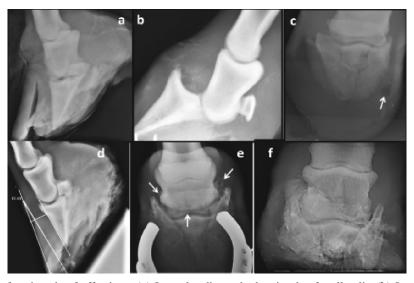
Radiographs of various hoof affections. (a) Lateral radiograph showing hoof wall split, (b) Lateral radiograph showing dislocation of coffin joint, (c) Dorso-plantar radiograph showing a smooth marginated, radiolucent defect in the solar region suggestive of solar abscess, (d) Lateral radiograph showing laminitis with severe rotation of coffin bone, (e) Dorso planter radiograph showing proliferative bone reaction and lytic changes in the navicular bone suggestive of navicular disease, (f) Dorso-palmer radiograph showing bone reaction in coffin joint.
